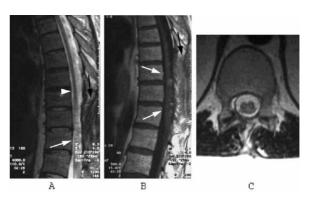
MR imaging of the same patient nine months later, after a multi-level laminectomy (black arrows) and spinal cord surgery. A) T2-weighted image in the sagittal plane shows reduced area of abnormal signal (white arrow) with less prominent spinal cord thickening in comparison with Fig. 1B. Spinal cord edema is no longer present (white arrowhead). B) T1-weighted image in the sagittal plane after application of gadolinium also shows reduction in size of the abnormality, with a number of smaller enhancing lesions. C) Fast spin-echoT2-weighted image in the axial plane at a similar level as in Fig. 1D shows definite regression, with minimal residual increased signal within the cord, and almost complete resolution of cord thickening.
